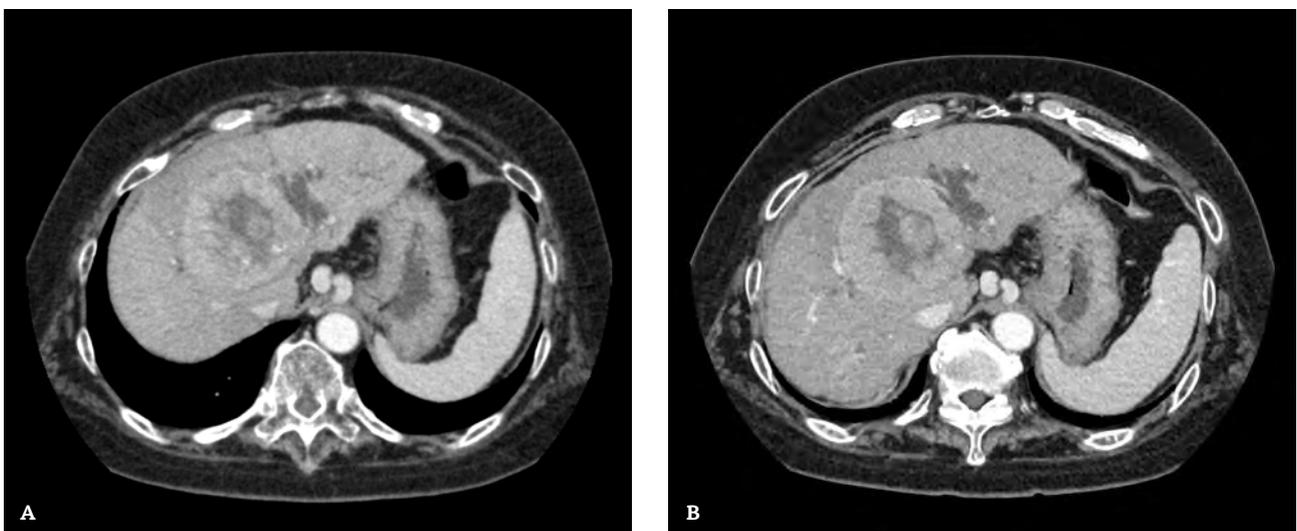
Improved liver lesion visibility on UHR CT images with similar radiation dose. AIDR 3D at 11.8mGy (A) compared to AiCE at 12.4 mGy (B).
